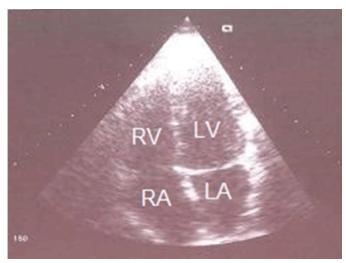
Transthoracic echocardiography four months after pulmonary endarterectomy: dilated right ventricle disappeared. [RV Right ventricle, LV Left ventricle, RA Right atrium, LA Left atrium
